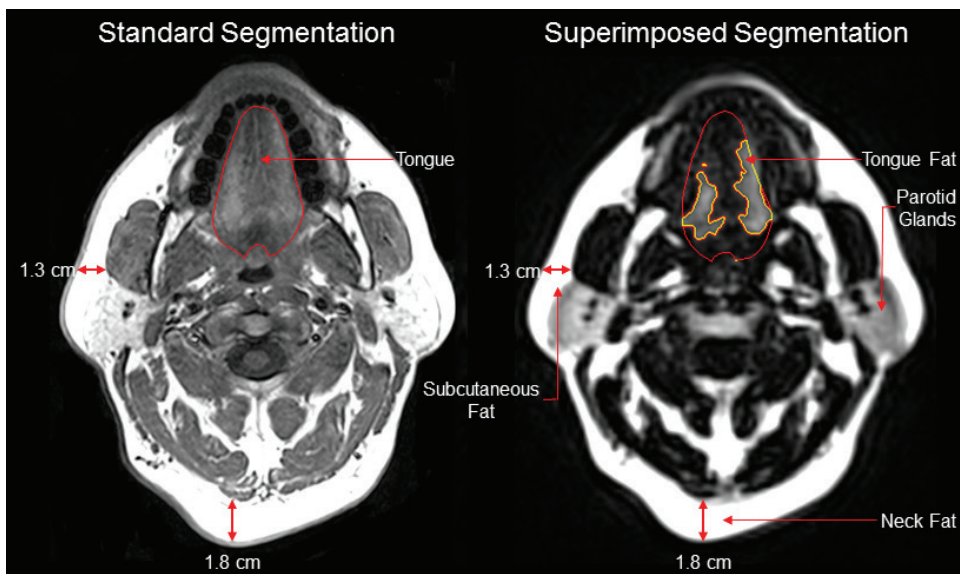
Axial standard T1-weight spin echo (left) and fat-weighted Dixon (right) MR images of the upper airway are shown above. Segmentation of the apneic tongue using standard T1-weighted spin echo MR image with superimposed segmentation on corresponding anatomic level of a Dixon image. Note that this correctly thresholded example shows comparable thicknesses of neck and subcutaneous fat within each image and visualization of parotid glands.
